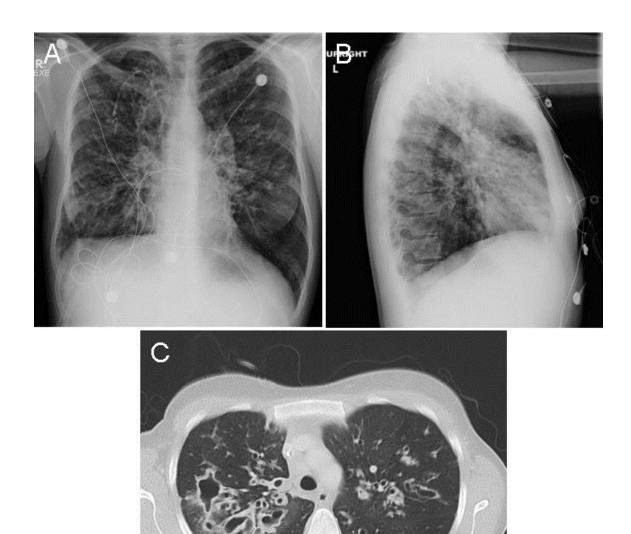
Previous PA (Panel A), lateral (Panel B) chest x-ray and representative image from the thoracic CT scan (Panel C).
